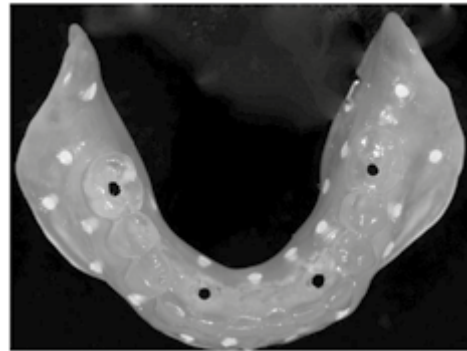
The new diagnostic removable prosthesis was duplicated to create an acrylic radiographic template.
